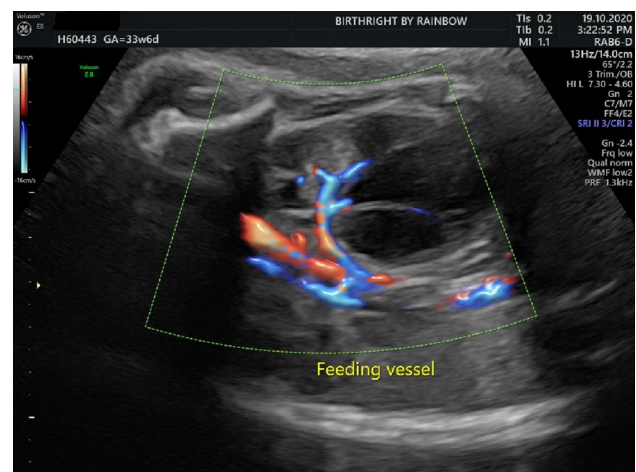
Colour Doppler interrogation
